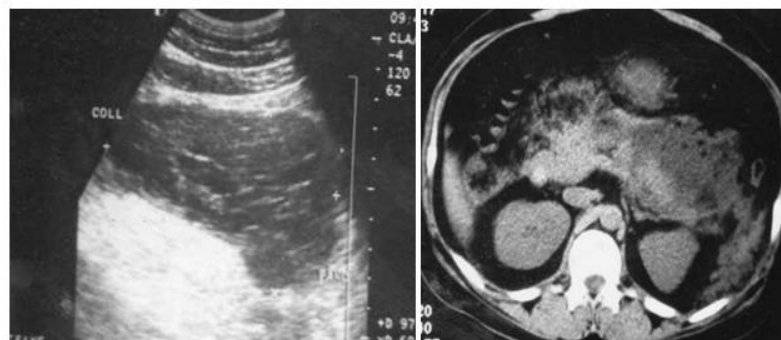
A & B : USG image shows hypoechoic septated collection in lesser sac with non- visualization of Pancreas. CT Scan image eliciting collection in Left anterior pararenal space and bulky tail of Pancreas with adjacent fat stranding
